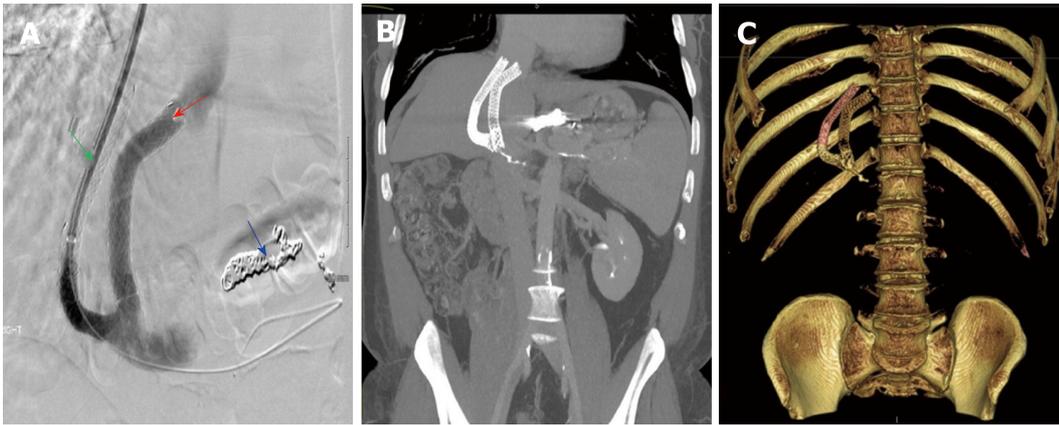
Treatment for patient 2. A: Digital subtracted portal angiography showing successful placement of the parallel stent (red arrow). Embolization coils can be seen the coronary vein branches (blue arrow). Primary stent (green arrow) is seen alongside the second transjugular intrahepatic portosystemic shunts stent. B: Maximum intensity projection with 30-mm slab of a post procedural computed tomography (CT) abdomen showing primary and parallel stents in tandem. C: 3D reconstruction of post procedural CT abdomen showing primary and parallel stents in tandem.
